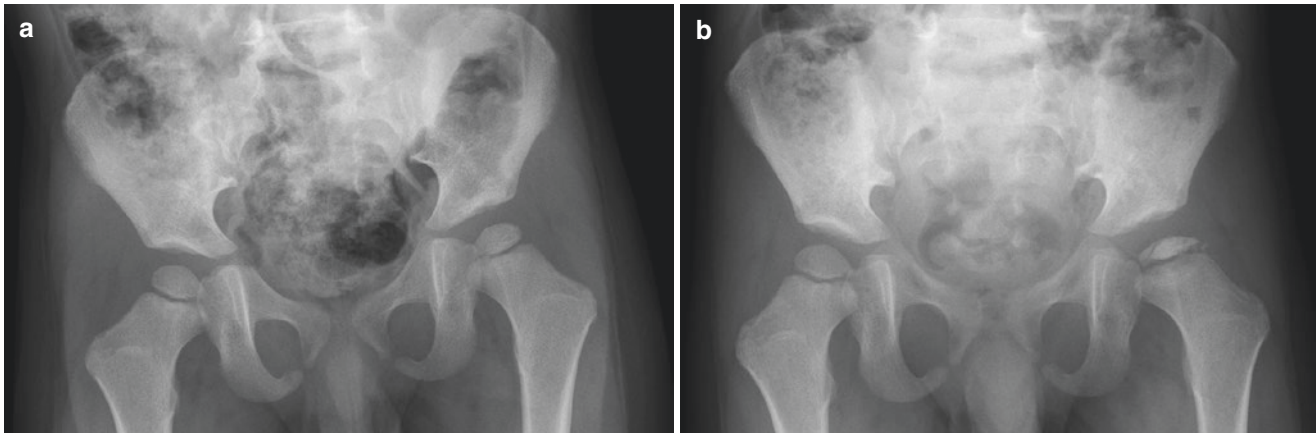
Pelvic X-rays in Perthes disease. (a) In the early phase, only subtle flattening and sclerosis of the epiphysis of the left hip is seen. (b) A few months later progressive flattening with fragmentation and sclerosis of the epiphysis has developed
